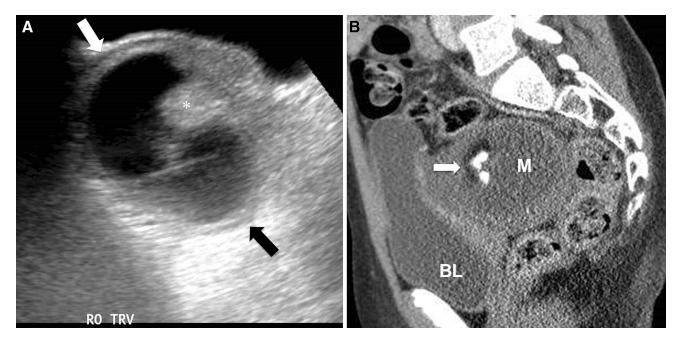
Transverse ultrasound image of the right adnexa (A) in a young female patient presenting with right lower quadrant pain shows a solid and cystic mass (*arrows*) with an echogenic mural nodule (*asterisk*). Sagittal CT image through
